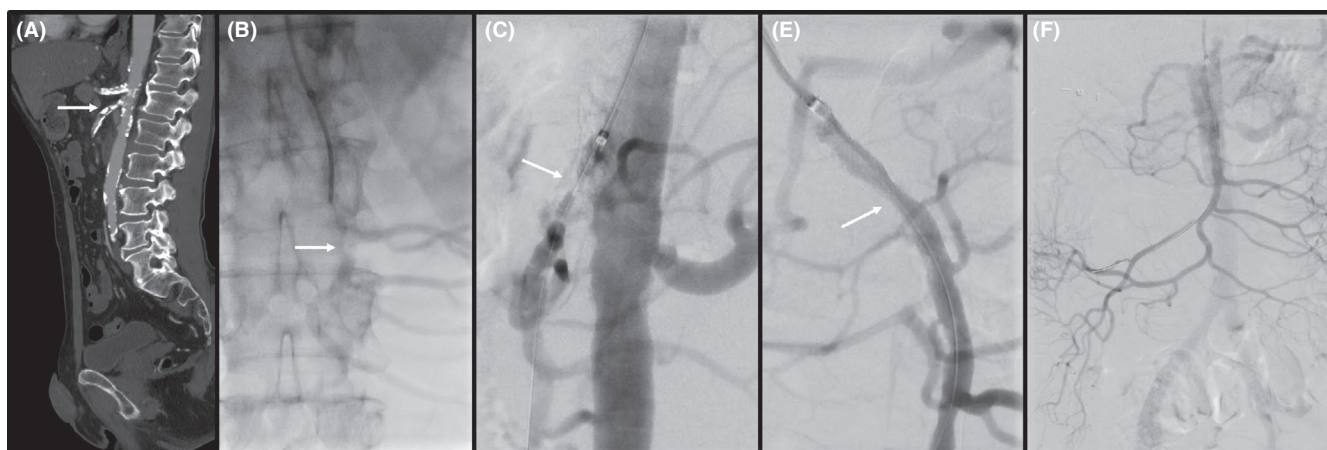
A, Chronic total occlusion of the celiac axis and superior mesenteric artery (SMA) in abdominal computed tomography; B, Sagittal view of the occluded SMA and its branches; C, SMA stenosis directly after balloon angioplasty; D, Remaining 30% SMA stenosis after stent implantation; E, Adequate mesenteric collateral circulation
